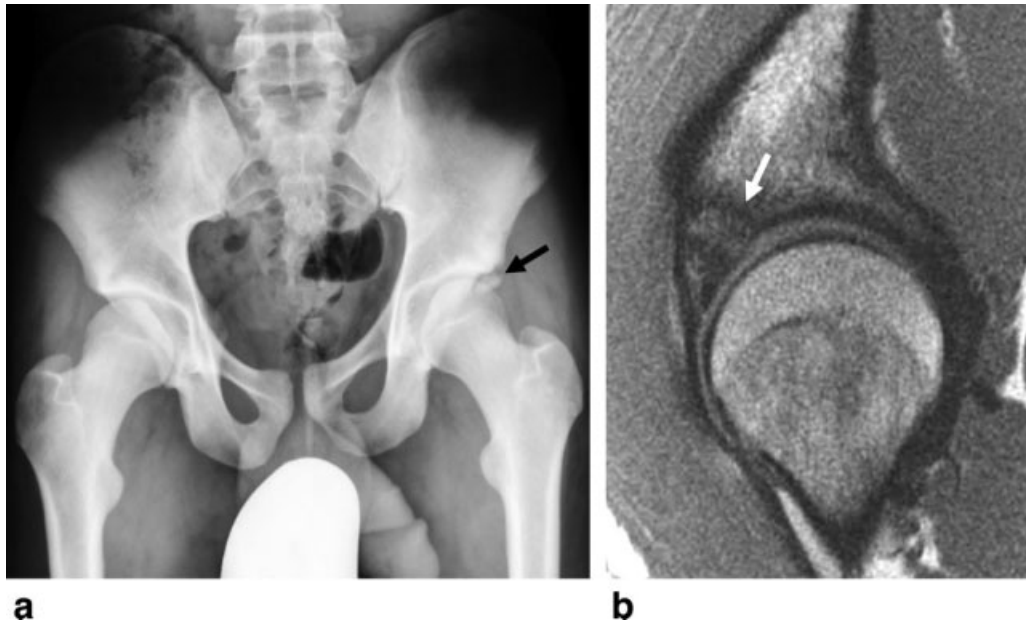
A,B: AP pelvis radiograph (A) and sagittal MR image (B) of an 18-year-old man with femoroacetabular impingement demonstrate chronic fracture through intralabral ossification (arrows) with adjacent stress reaction in the acetabular dome.
